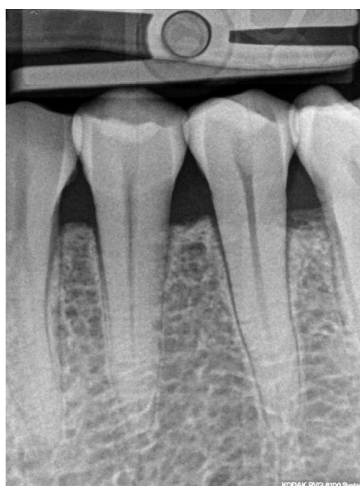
The direct digital intraoral periapical radiograph of the mandibular premolar region of a patient obtained using paralleling technique
